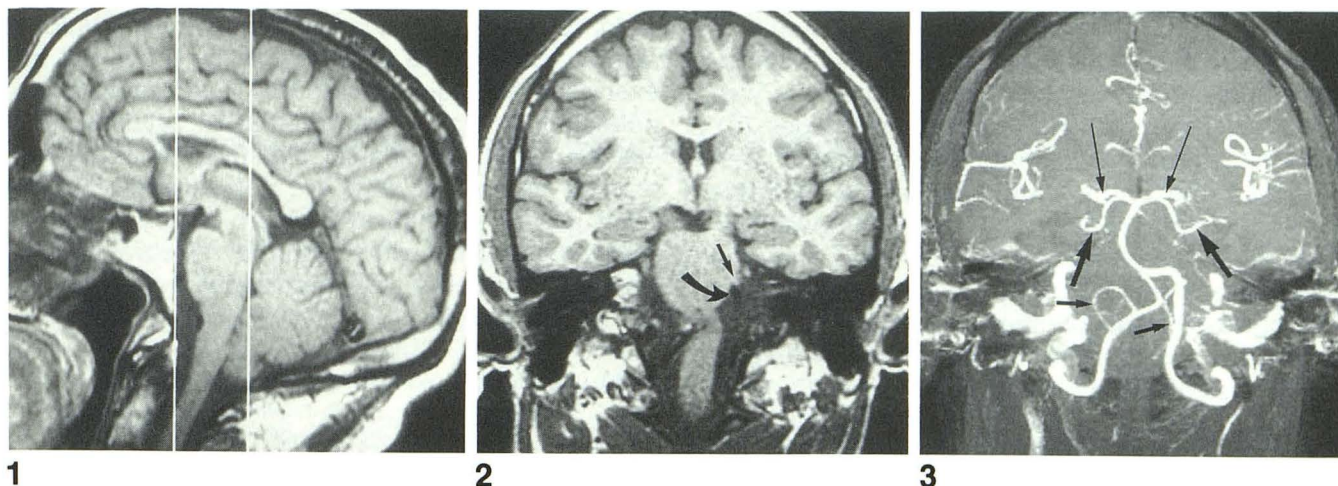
Sagittal T1-weighted localizer image (500/20/1) shows the clivus is parallel to the floor. The two lines represent the area of coverage from the cortex of the clivus to the floor of the fourth ventricle.
